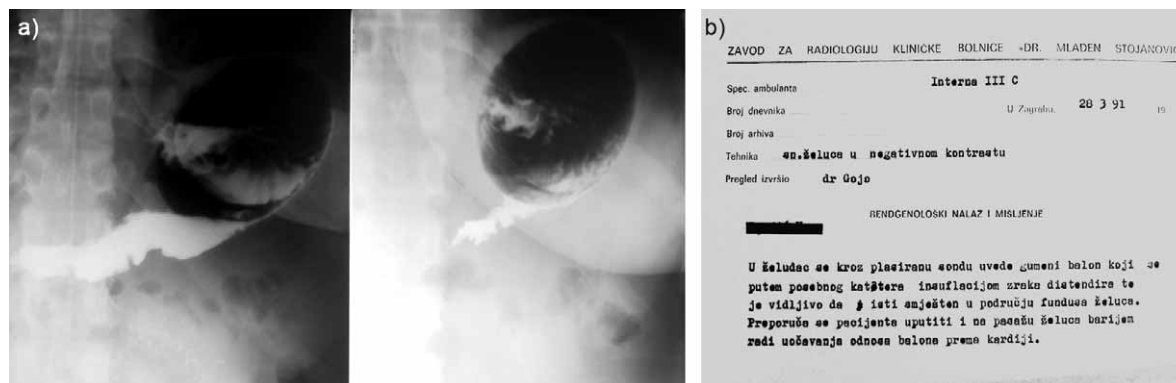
First series of intra-gastric balloons implanted in »Sestre Milosrdnice« University Hospital Center (formerly Mladen Stojanovic) 20 years ago; a) native abdominal X-ray, b) radiology report.
